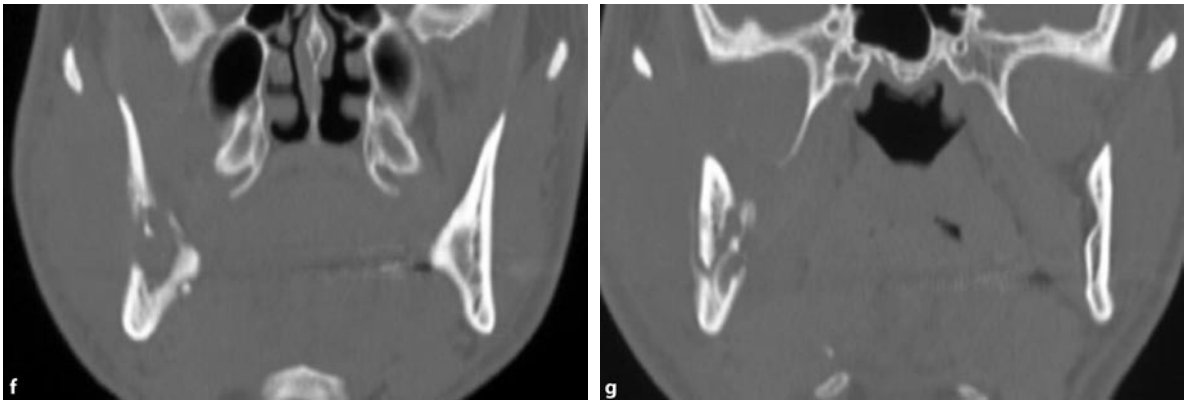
g (continued) The dorsal part of the mandibular angle has undergone sequestration as well as part of the coronoid process, as is also shown by coronal high-resolution bone-window CT images (f,g). Note linear
